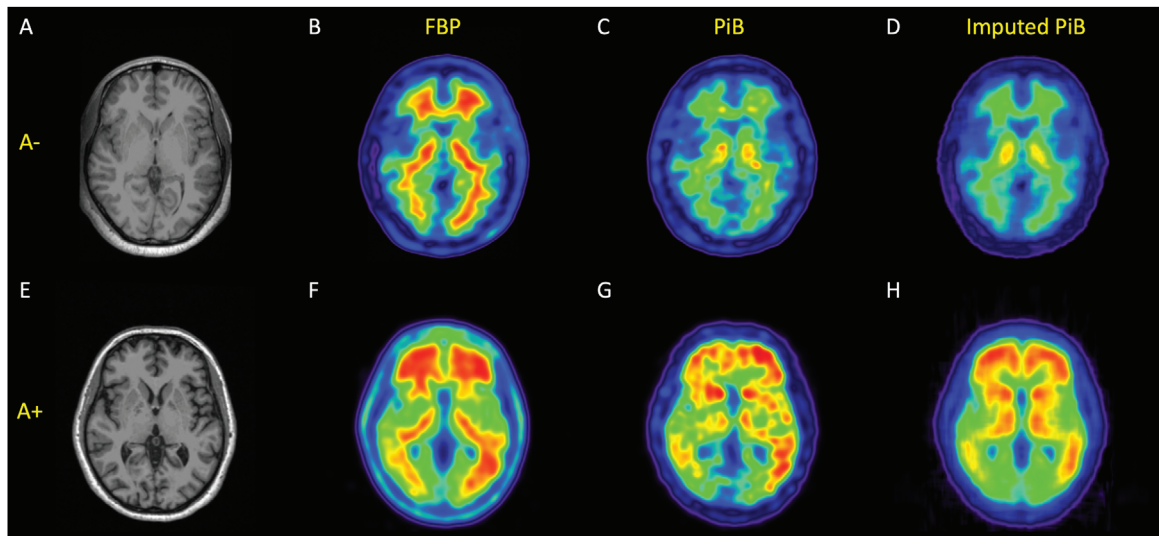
Example images for an amyloid negative participant (A-D) and an amyloid positive participant (E-H) from the independent testing dataset. T1-weighted image (A,E), florbetapir (B, F), PiB (C, G), and imputed PiB from florbetapir (D, H). The difference between florbetapir and PiB images can easily be observed including the substantially higher white matter uptake in florbetapir than PiB. The imputed PiB images from florbetapir demonstrated substantially improved similarity with true PiB data.
